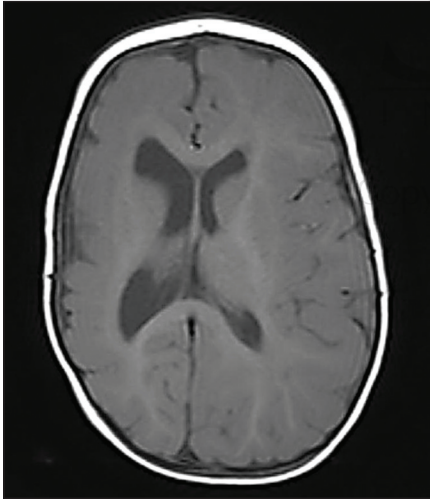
Magnetic resonance imaging scan of brain of an infant born with congenital cytomegalovirus (CMV) disease involving the central nervous system. This infant had microcephaly, hemiparesis, mild to moderate developmental delays, seizures, and unilateral sensorineural hearing loss. Imaging showed right-sided polymicrogyria, a cortical maldevelopment syndrome that may be associated with congenital CMV disease of the brain. This child was treated with oral valganciclovir, underwent hemispherectomy, and is now ambulatory, seizure free, and has mild to moderate developmental delays.
